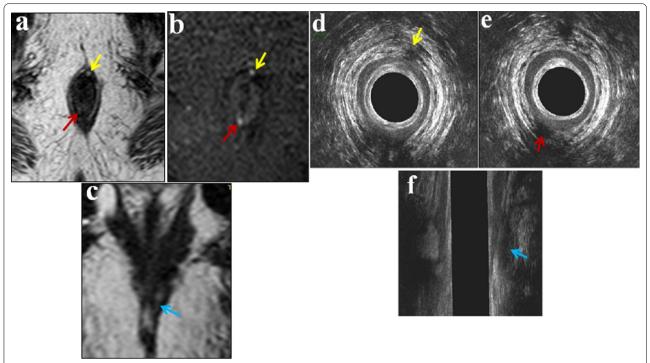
a, b MRI axial T2 and STIR WI images showing two fluid filled intersphincteric fistulous tracts eliciting high signal and abutting the internal sphincter at 1 o'clock (yellow arrows) and 6–7 o'clock (red arrows). c Coronal T2 MRI WI images showing left intersphincteric fluid filled fistulous tract (blue arrow). d Ultrasound images show a hypoechoic fistulous tract seen within the left anterior intersphincteric space abutting the internal anal sphincter (internal opening) opposite 1 o'clock (yellow arrow). e Another hypoechoic fistulous tract seen within the right posterior intersphincteric space abutting the internal sphincter opposite 6–7 o'clock (Red arrow). (f) Ultrasound coronal images show left short intersphincteric fistulous tract breaching the internal sphincter at the level of the superficial portion of the external sphincter (blue arrow)
